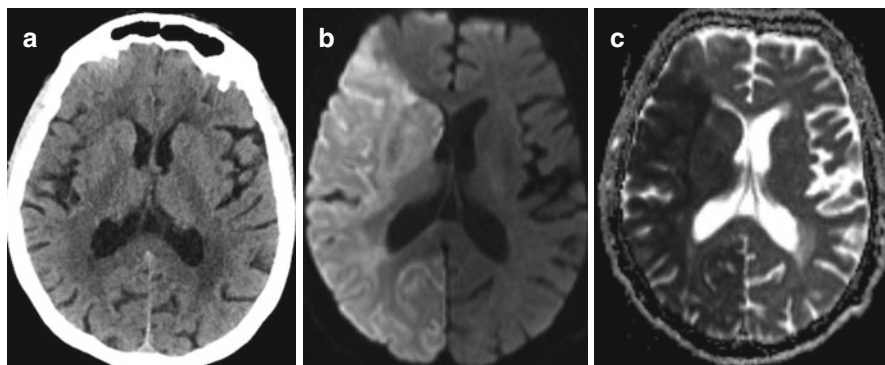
(a–c) Large hyperacute infarction in the right MCA and PCA territories. CT scan shows no pathological changes (a). Diffusion-weighted MR image (b) shows the area of high signal intensity in the right hemisphere except for the medial part of the frontal lobe. ADC map (c) shows decreased ADC values in the same area. These findings are indicative of acute infarction
